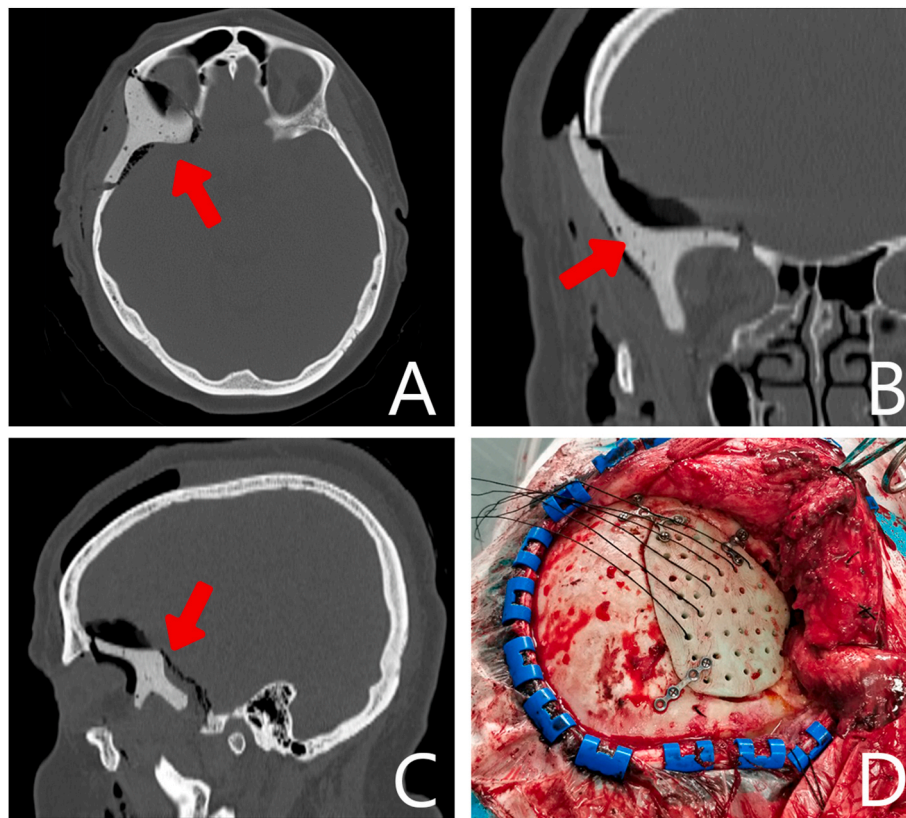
Patient 3. (A–C) Post-op CT scan. (D) Intraoperative picture.
